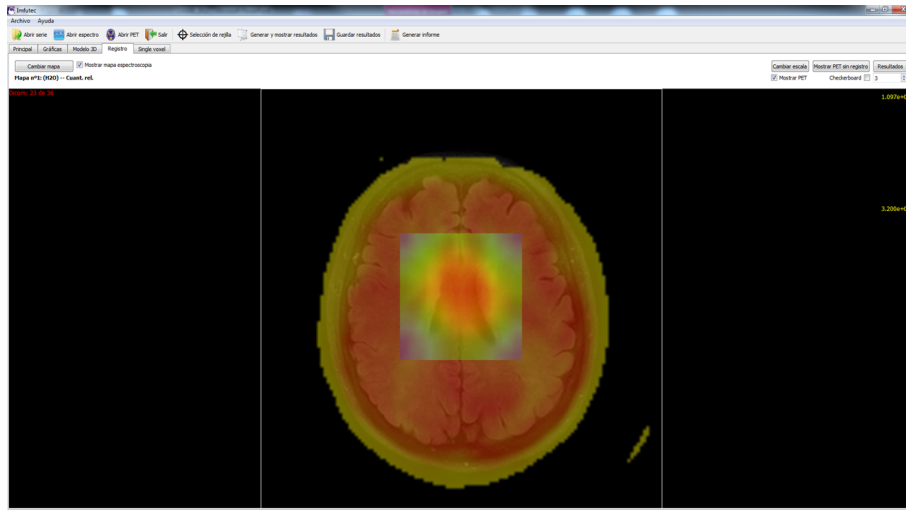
MRI-CSI-PET registration in IMFUTEC
